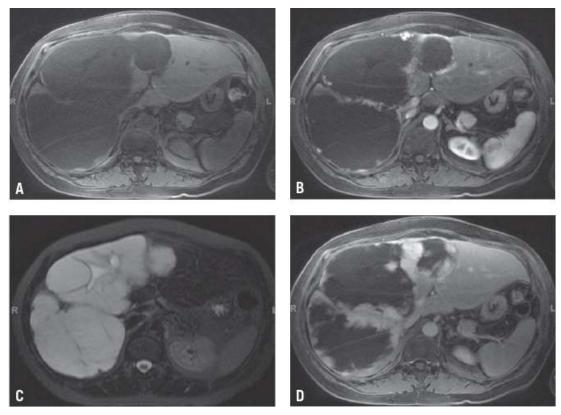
Large cavernous hemangioma. Characteristic peripheral interrupted puddling that progresses during dynamic imaging (A,B,D) along with the characteristically bright signal intensity on T2-weighted imaging (C) provides a definitive diagnosis of hemangioma on MRI.
